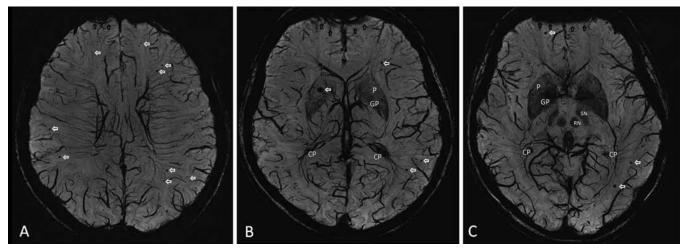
Axial slices of susceptibility weighted MR images with MIP in a 34-year-old man with confirmed familial CCM revealing multiple hypointense lesions (several labeled with *small white arrows*) suggestive of CCM. CP = choroid plexus; GP = globus pallidus; P = putamen; RN = red nucleus; SN = substantia nigra. The *small black arrows* denote the signal cancellations caused by the adjacent frontal sinus.
